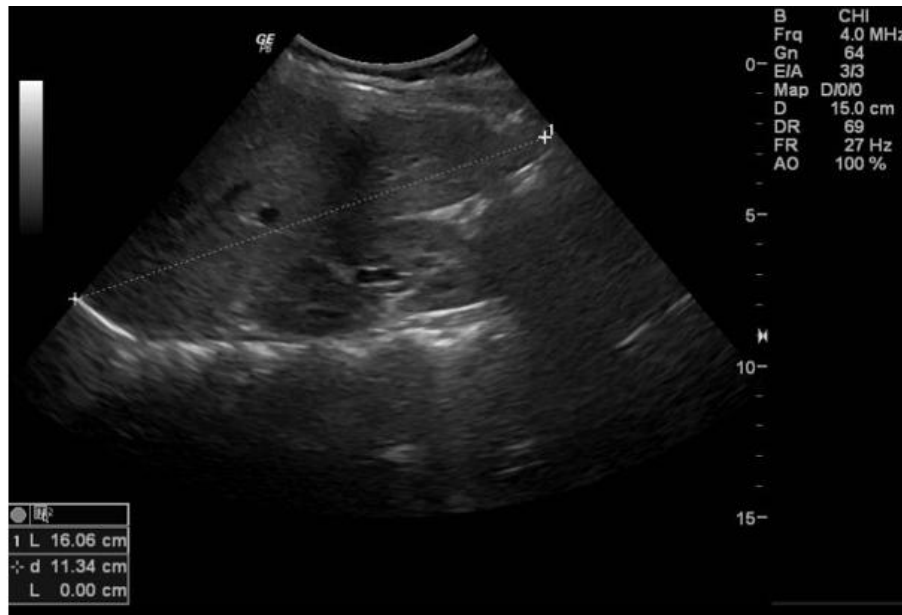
Abdominal ultrasound shows normal liver.
